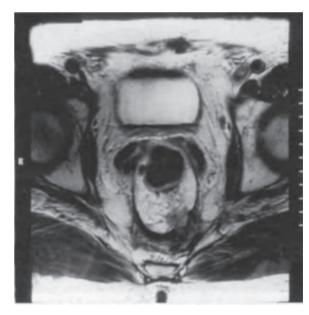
MRI of the rectum obtained using phased array pelvic coils.
